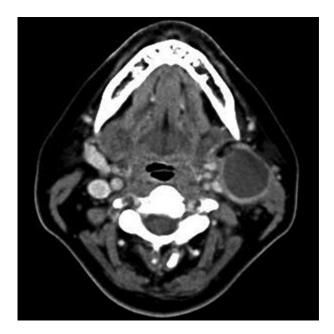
Axial computed tomography scan showing a hypodense lesion in the left neck.
